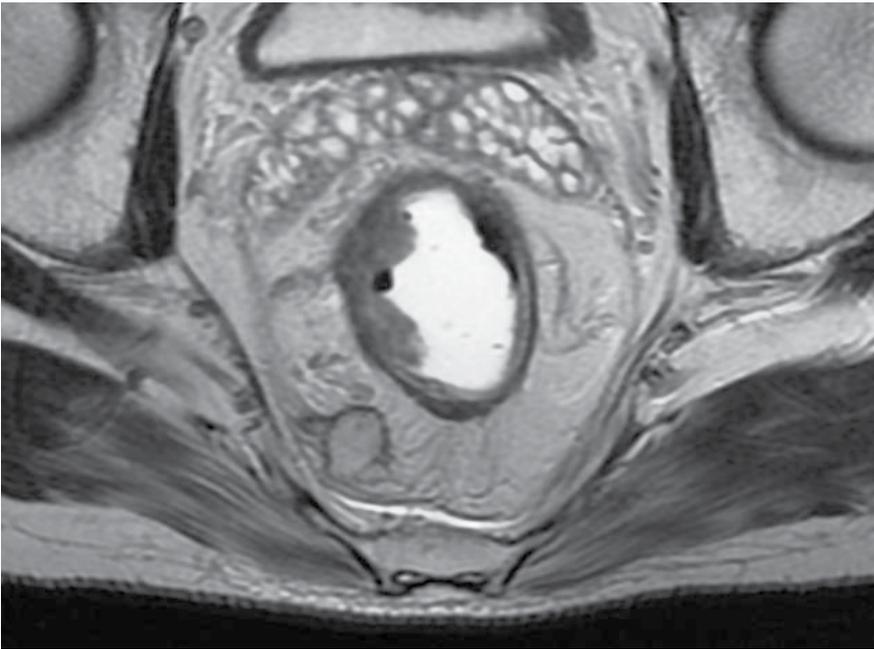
Pelvic MRI T2 sequence, axial plane showing a rectal mass with a lymph node in the mesorectum.
